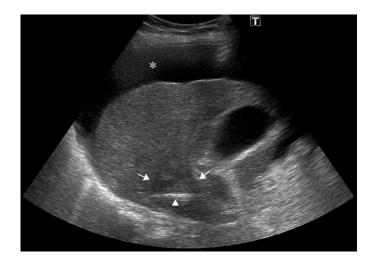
Ultrasonography image. A large amount of ascites is observed between the abdominal wall and the liver surface (asterisk). A biopsy needle, which appears as a linear high intensity (arrowhead), is inserted into the target tumor (arrows), which is depicted as a low echo.
